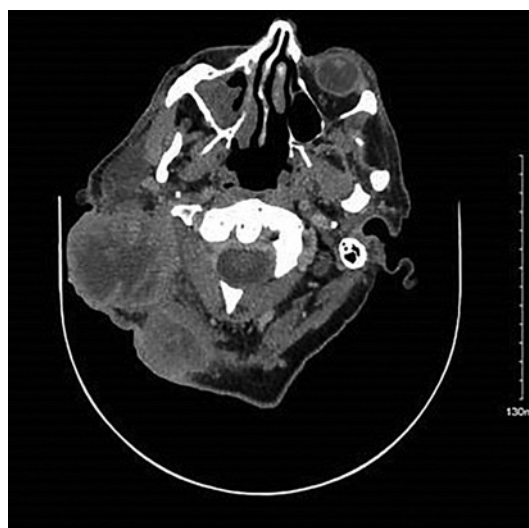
Axial slice of contrast-enhanced CT neck pre-treatment showing large necrotic adenopathy in right posterior triangle with muscle invasion.
